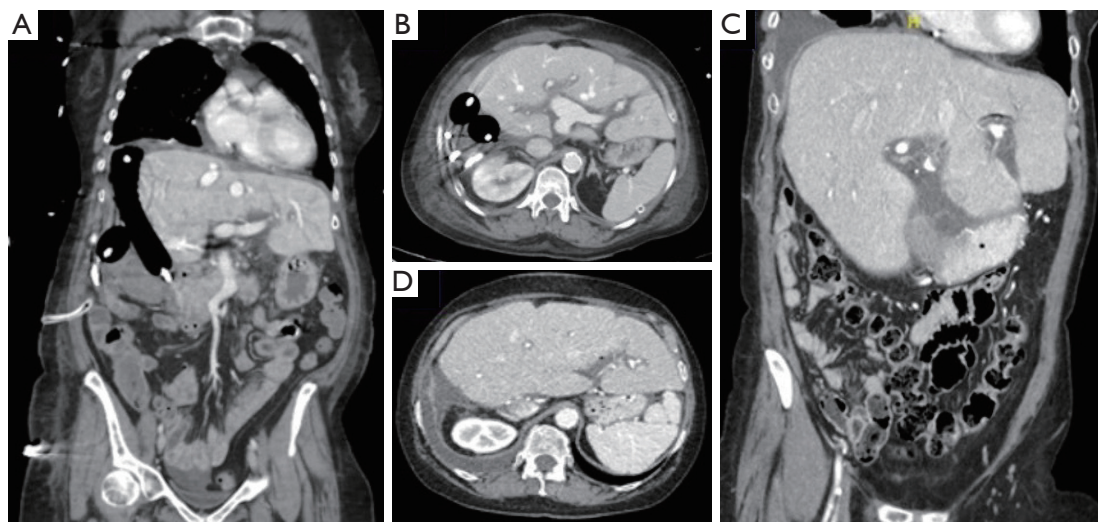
Postoperative CT scan image, at the postoperative day 2, showing the Blakemore tubes placed during liver transplantation to rescue the caval outflow (A,B). Control CT scan after Blakemore tubes removal at the postoperative day 10 (C,D).
